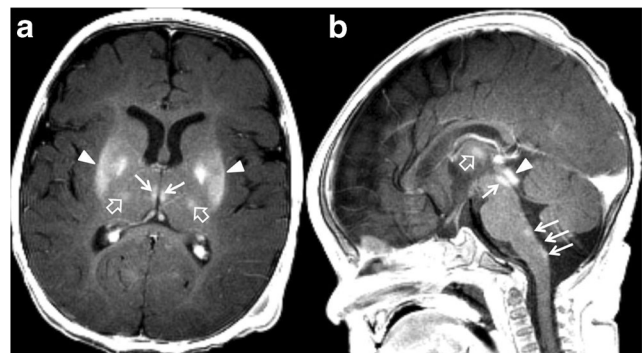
A 4-month-old male 7 days status post-cardiac arrest. Post-contrast axial T1-weighted image demonstrates selective contrast enhancement of the basal ganglia with preservation of the capsules (a, arrowheads), medial thalamic nuclei (a, arrows), cortical-spinal tracts (a, open arrows). Mid-sagittal post-contrast T1-weighted image demonstrates multifocal enhancement in the central gray matter (b, arrows), thalamus (b, open arrow), and tectal plate (b, arrowhead). Areas of enhancement reflect selective blood-brain barrier damage following cardiac arrest-related brain hypoxia. Interestingly, similar anatomical brain regions are affected in Wernicke encephalopathy, secondary to thiamine (vitamin B₁) deficiency
